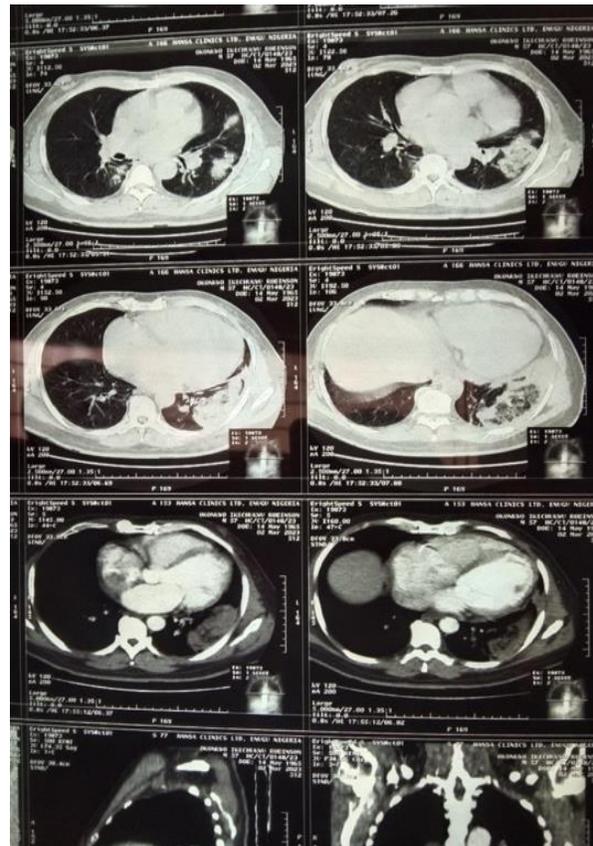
Chest CT scan showing consolidations had reverse halo sign.
